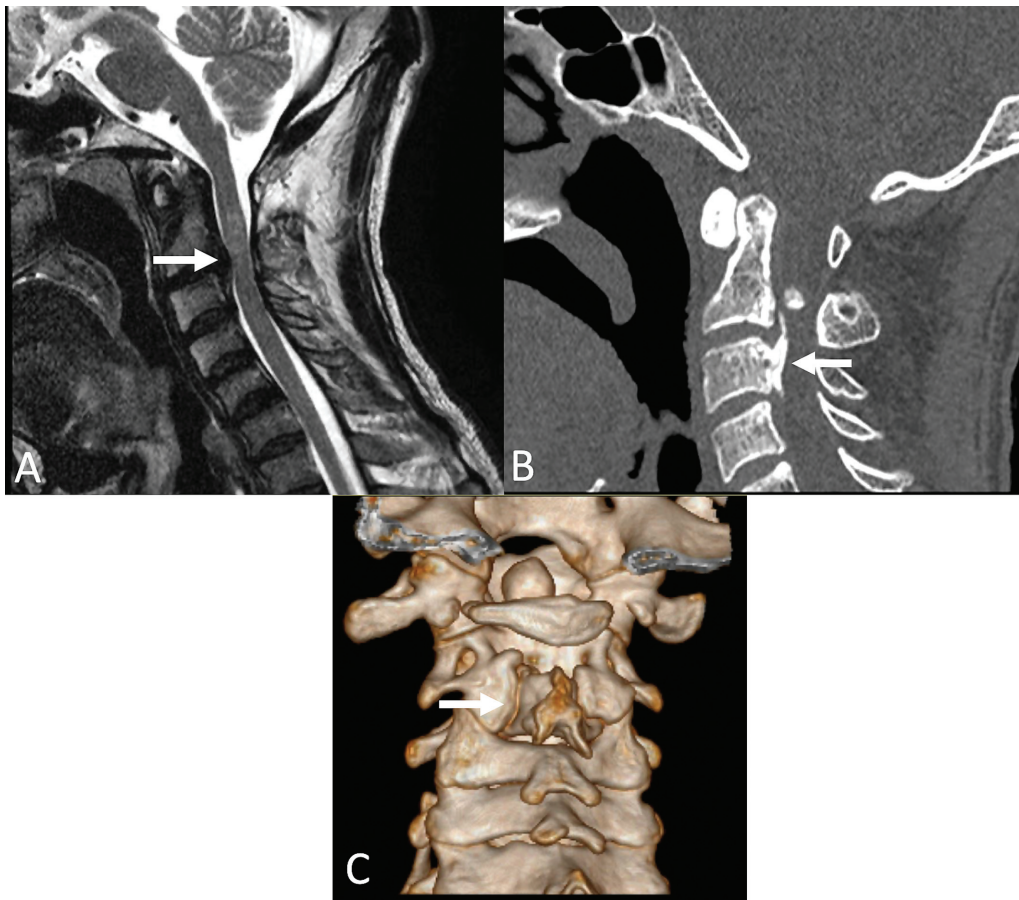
(A) Magnetic resonance imaging (MRI) revealed circumferential cord compression with canal stenosis with features of myelomalacia (arrow). (B) Computed tomography (CT) showing ossified posterior longitudinal ligament (OPLL) at the level of (arrow). (C) Three-dimensional (3D) view showing unfused C2 lamina (arrow).
